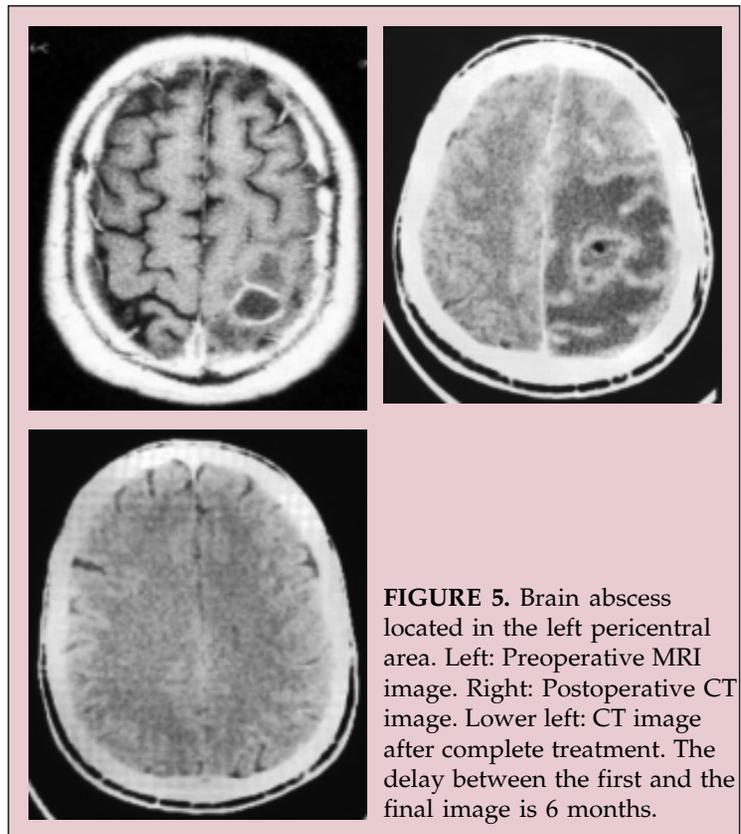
Brain abscess located in the left pericentral area. Left: Preoperative MRI image. Right: Postoperative CT image. Lower left: CT image after complete treatment. The delay between the first and the final image is 6 months.
